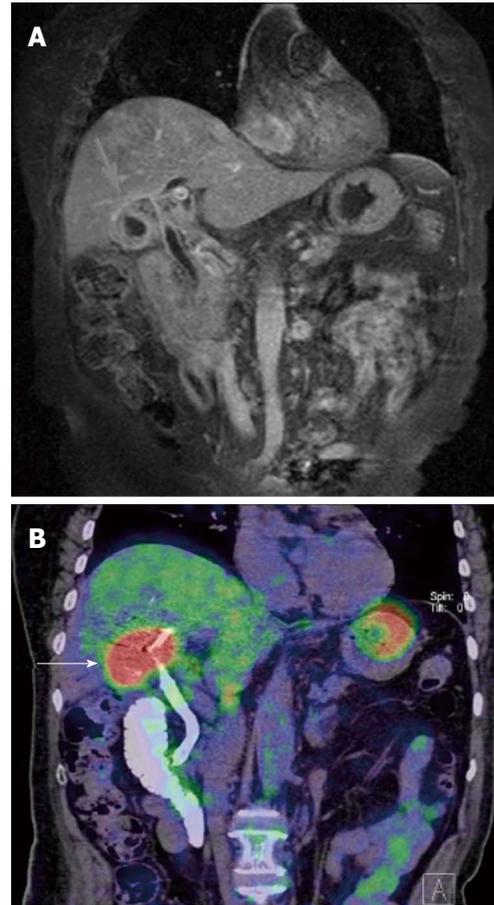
A case of acute cholecystitis. A: CE-MRI (coronal section) shows irregular wall thickening of gall bladder (arrow) with hilar bile duct stenosis; B: PET/CT performed after PTC. Gall bladder shows strong FDG accumulation (arrow) although pathological diagnosis was acute cholecystitis. Discrimination between active inflammation and tumor is difficult using accumulation of fluorodeoxyglucose.
